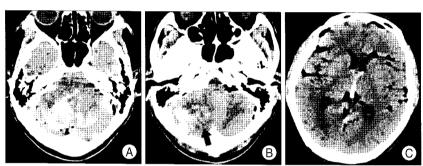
A non-contrast computed tomography scan demonstrates acute hemorrhage in the cerebellar vermis and both hemispheres (A), a streaky and curvilinear bleeding pattern with blood in the cerebellar sulci facing the tentorium (zebra sign) (arrow) (B), intraventricular hemorrhage at 3rd ventricle, and profound pneumocephalus (C).
